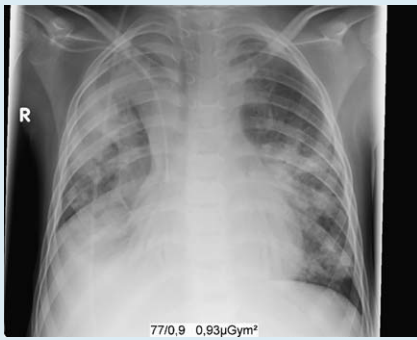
Chest radiograph displaying severe pneumonia with extensive bilateral patchy infiltrates.
